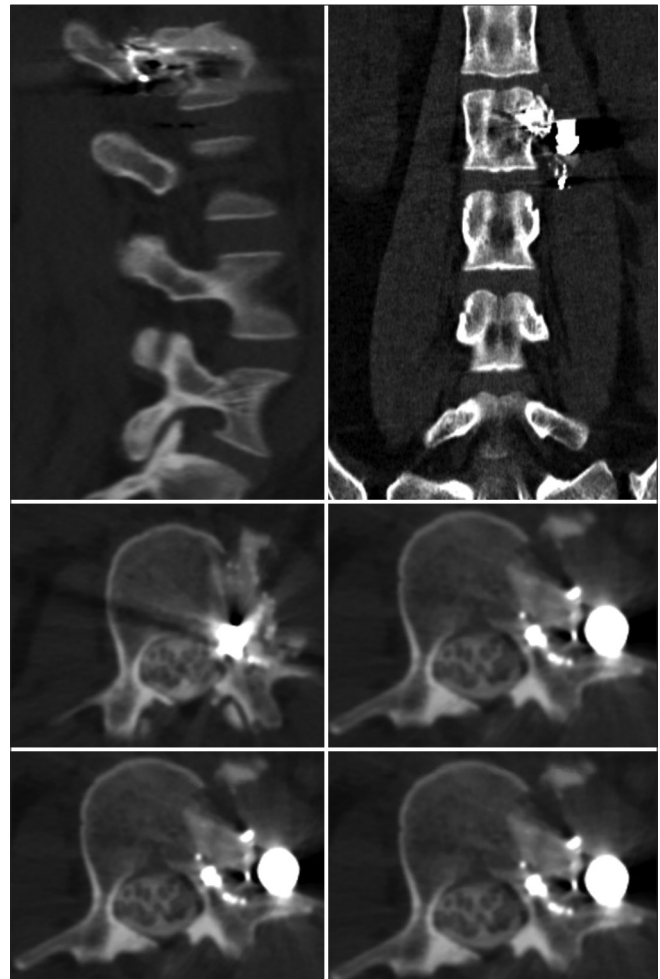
Sagittal, coronal, and axial CT myelogram images showing anterolateral cerebrospinal fluid fistula, with leakage of contrast into the left psoas muscle.
